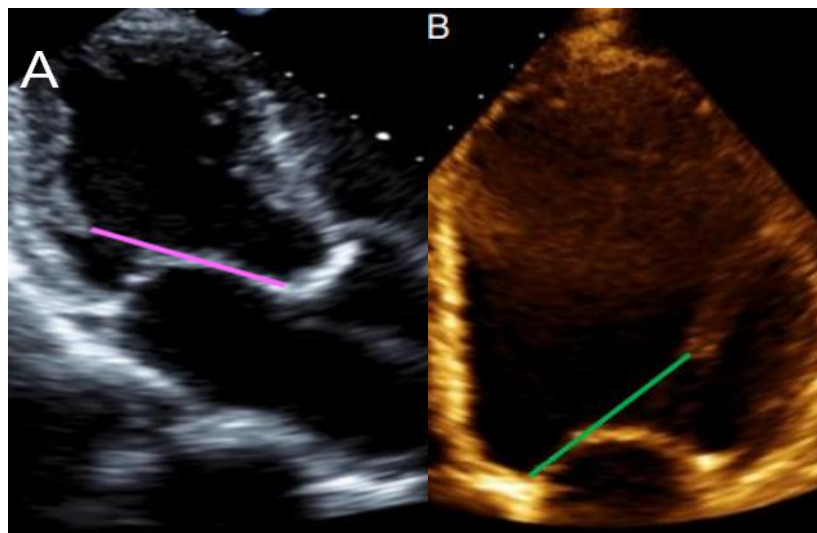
(A) Apical displacement of the posteromedial PM in the apical three chamber view (B) the apical displacement of the anterolateral PM in the apical 4 chamber view.
